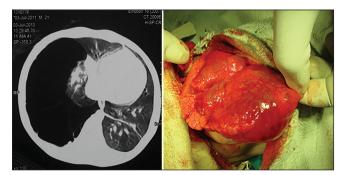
Coronal section of computed tomography showing right sided congenital lobar emphysema with intra-operative excision
